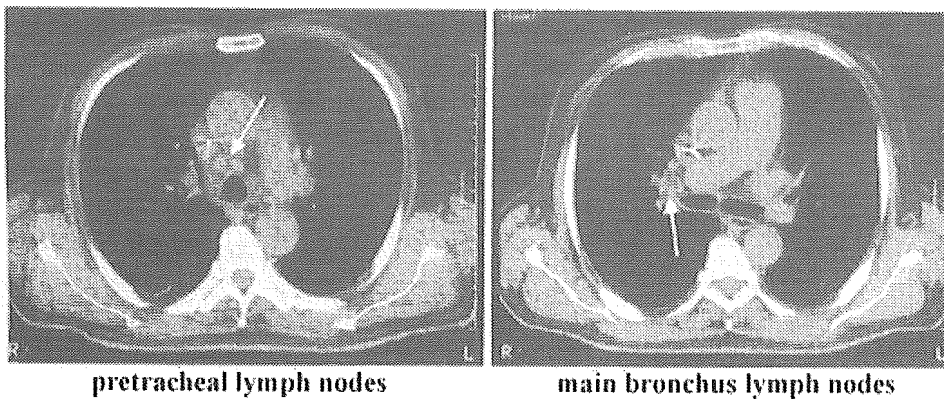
Computed tomography at the time of left ventriculoplasty reveals the swelling of mediastinal lymphnodes, including pretracheal and main bronchus lymphadenopathy (arrows).
